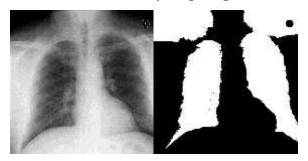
Image processing result for sample of normal X-Ray lung image .
